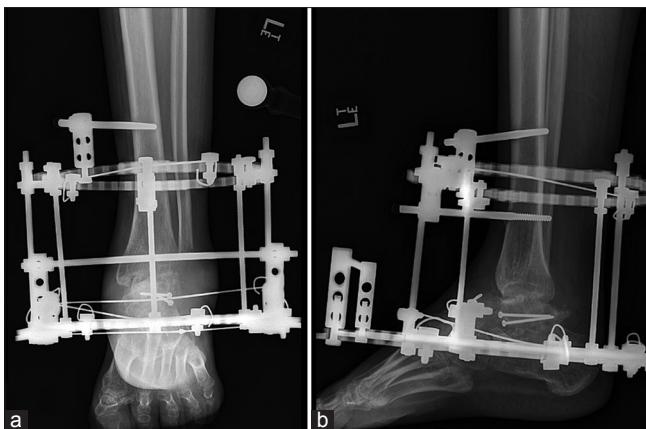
The final frame construct and reduction are seen on this anteroposterior (a) radiograph taken immediately postoperative. The arched wires indicate strong axial compression on both the ankle and subtalar fusion sites. Both fusion sites are well visualized on this immediate postop lateral (b) radiograph
